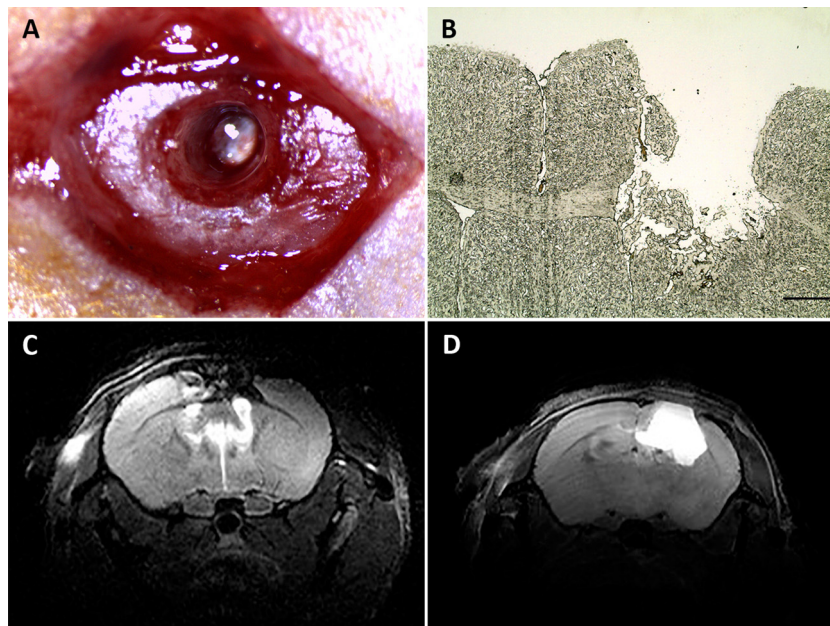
A: Cavity, immediately post-resection and cleared of blood, showing a defined edge; B: Cryosectioned brain immediately following resection; C: MRI scan following resection at day 7 showing the extent of tissue removal; D: MRI scan at day 7 post resection, showing fluid build-up within the resection cavity, indicated by the hypersignal. Scale bar in B = 400 μ m.
